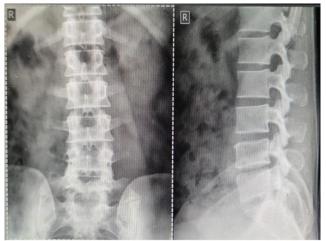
X-ray spine shows early lumbar spondylosis. That was the main cause of muscular
